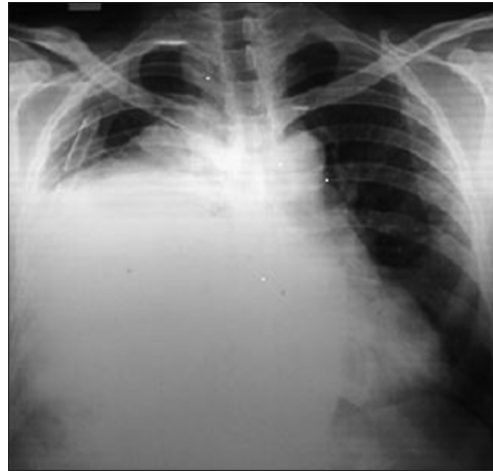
Chest X-ray PA view; Post-ICD day-1, showing ICD *in situ* with soft tissue density with concave margins left side in para-cardiac region extending from the abdomen into thoracic cavity
